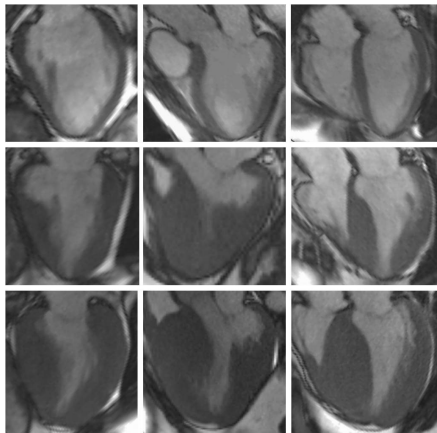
Sampled segmented trueFISP two-dimensional cine MR images of two- (first column), three- (second column) and four-chamber (last column) at end-diastole (ED) phase in a 50 years old healthy male subject (top row), 65 years old female HCM patient without obstruction (middle row) and a 48 years old male HCM patient with obstruction.
